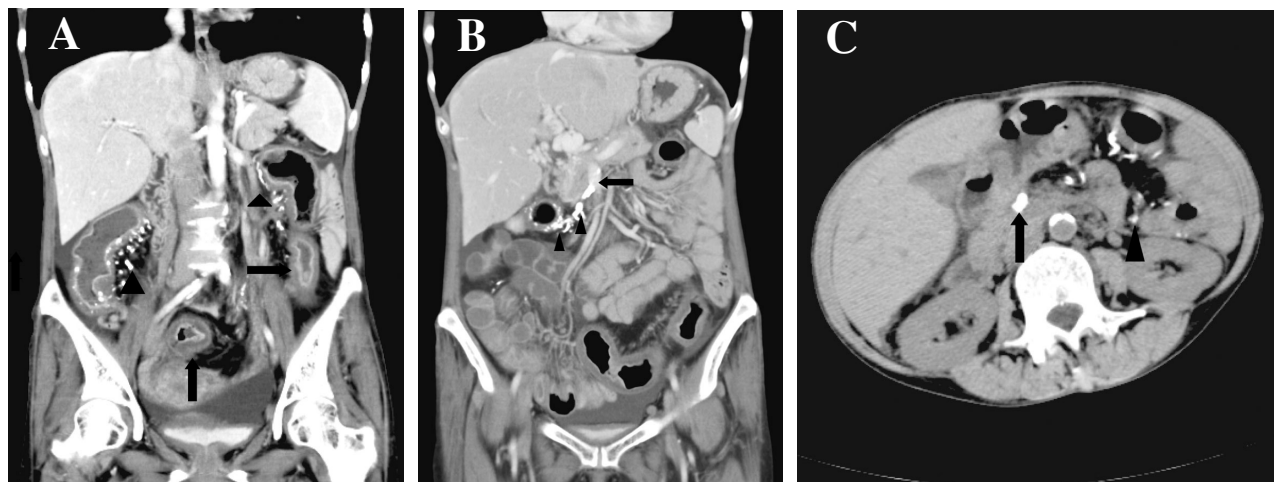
CT images disclose calcifications of the small mesenteric veins along the colonic wall, extending to the superior mesenteric and inferior mesenteric veins, as well as edematous thickening of the colonic wall from the terminal ileum to the rectum. (A) Enhanced CT reconstructed coronal image shows calcifications (arrowheads) along the colonic walls and edematous thickening (arrows) of the ascending, descending and sigmoid colonic walls. (B) Enhanced CT reconstructed coronal image shows calcifications (arrowheads) within the mesenteric veins extending into the superior mesenteric vein (arrow). (C) Enhanced axial CT shows calcifications at the superior mesenteric vein (arrow) and inferior mesenteric vein (arrowhead).
